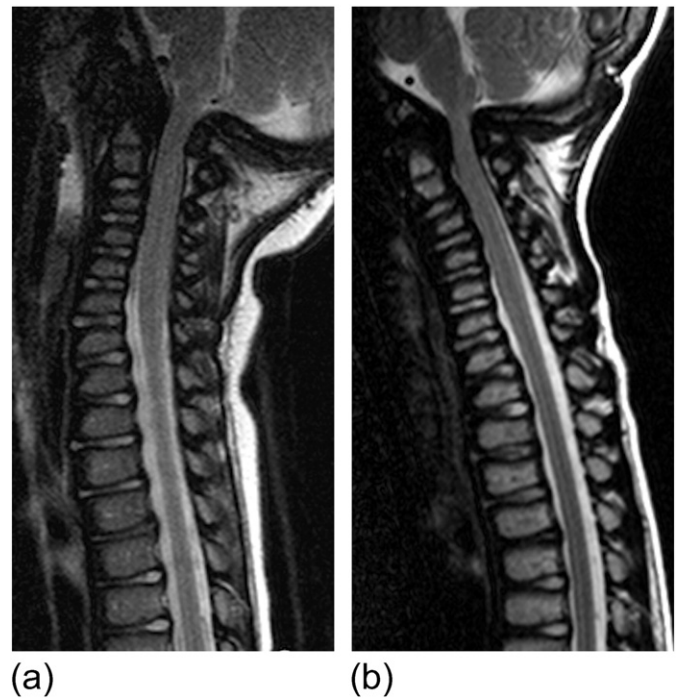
This 4 year old MPS VI subject with asymptomatic cervical cord compression at C1 has been followed for 4 years without progression. There are regular neurological assessments and imaging studies to monitor for myelopathic symptoms, cord compression, and development of instability. (a) Cervical spine MRI. At 4 years of age, this T2 TSE sagittal shows odontoid dysplasia, thickening of the cruciate ligaments, and hypoplasia of C1. There is effacement of CSF and mild cord compression. (b) Cervical spine MRI. At 8 years of age, this follow-up T2 TSE shows a decrease in space available to the cord from 7 mm to 6 mm without change in normal T2 cord signal. The slight decrease was attributed to differences in flexion and extension during the studies. No surgical intervention was planned and the subject continued with monitoring.
